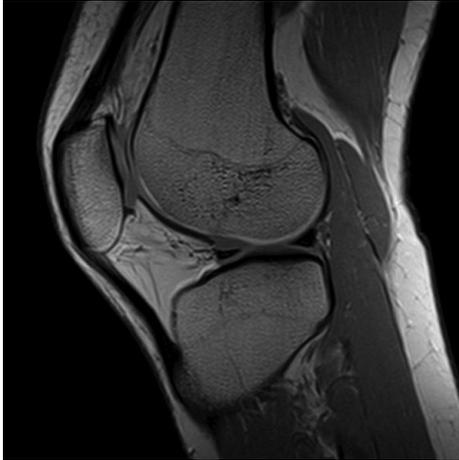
Normal MRI Scan
